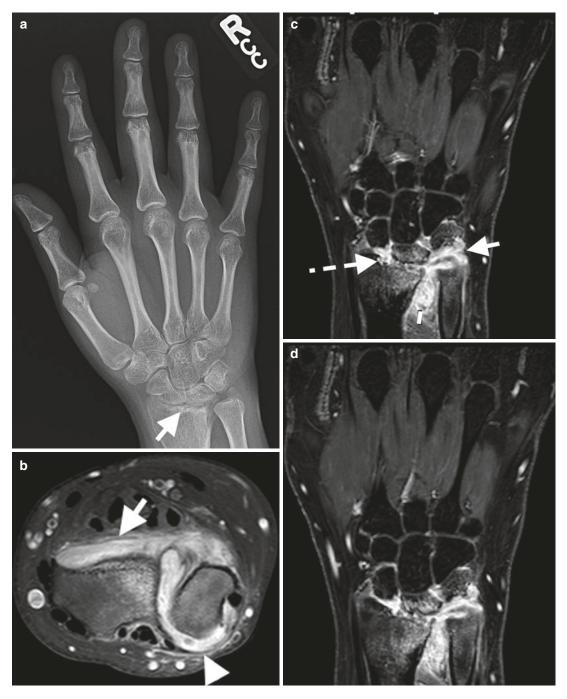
A 23-year-old female with RA and bilateral symmetrical erosive disease wrists. (a) AP hand demonstrating periarticular osteopenia, radiocarpal joint space loss and erosions of the lunate and radius (b) Axial T2FS MRI of the wrist with high SI fluid vs. synovitis distal
